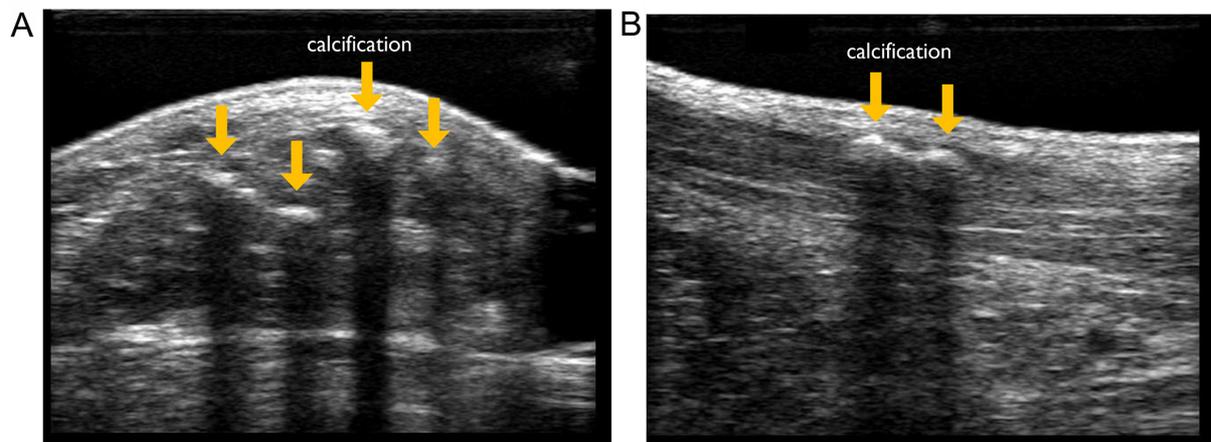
Ultrasonogram of Achilles tendon calcification for patient with familial hypercholesterolemia. (A) Horizontal sonographic appearance; (B) Sagittal sonographic appearance.
